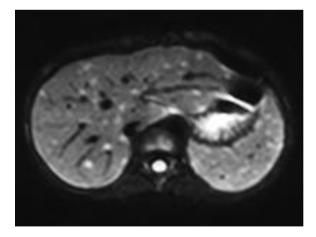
In case 1, diffusion-weighted magnetic resonance imaging showed multiple cystic lesions in the liver and spleen.
